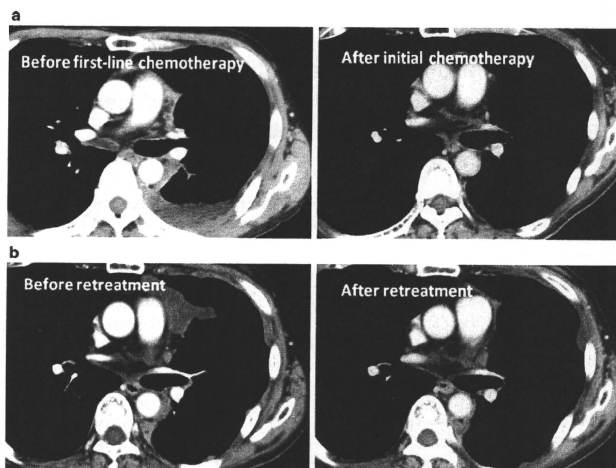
Responses of patient 1 to first- and second-line chemotherapy with cisplatin plus pemetrexed. Computed tomography scans revealed that pleural nodules of patient 1 showed a partial response to first-line
